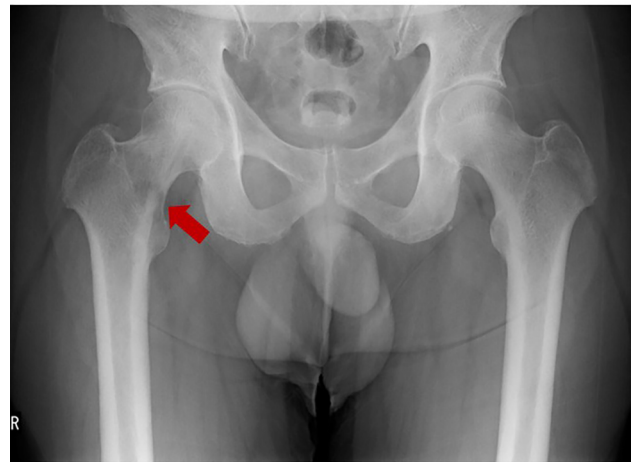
Plain X-ray showing a radiolucent area at the lesser trochanter.
